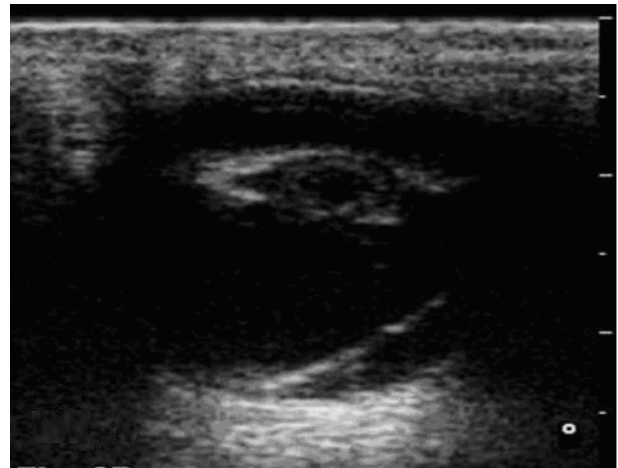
Ultrasonographic image showing retraction of vitreous with intact retina and cortical cataract
